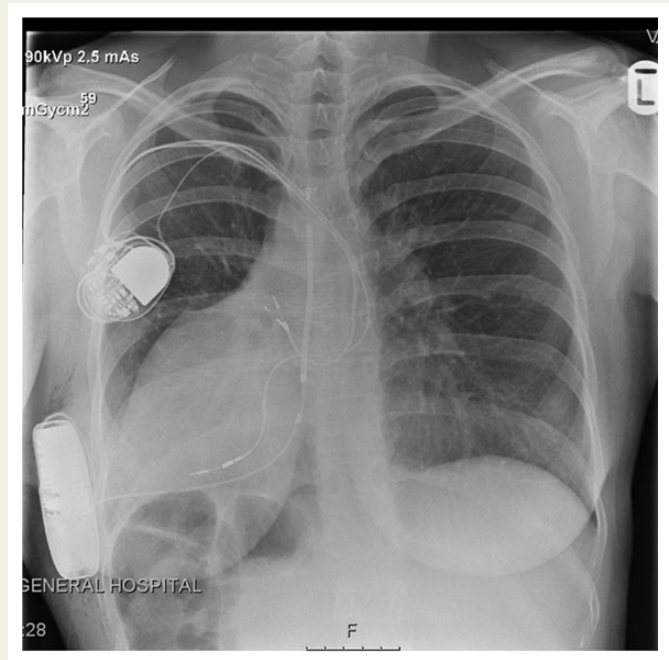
Chest radiograph showing dextrocardia and situs inversus with a right-sided S-ICD and dual chamber pacemaker.
